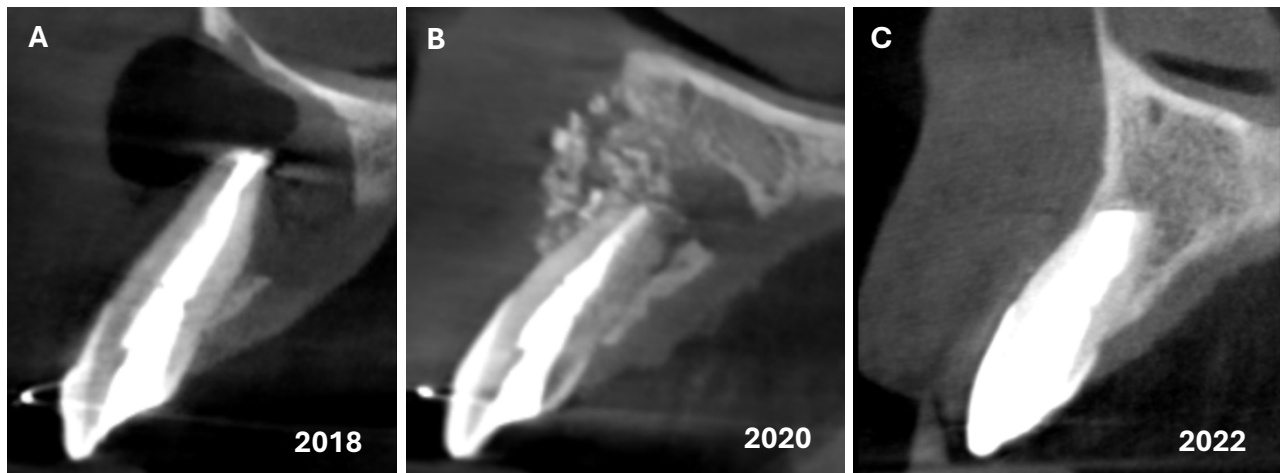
Comparison of sagittal CBCT scans of the tooth 22 upon different treatment by different doctors with assessment of long-term results two years after the microsurgery (C). (A) 2018; (B) 2020; (C) 2022.
